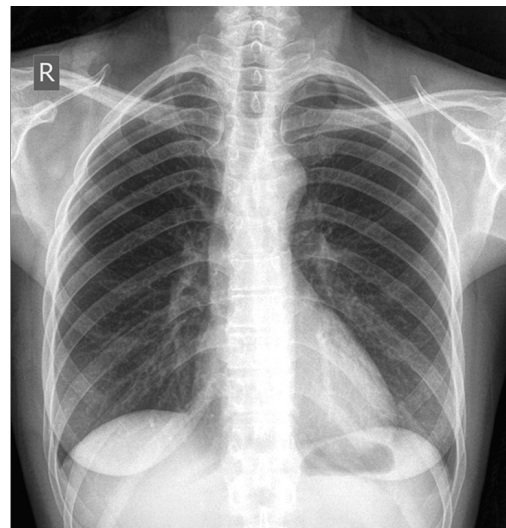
Postoperative follow-up with normal chest radiography with no signs of recurrence
